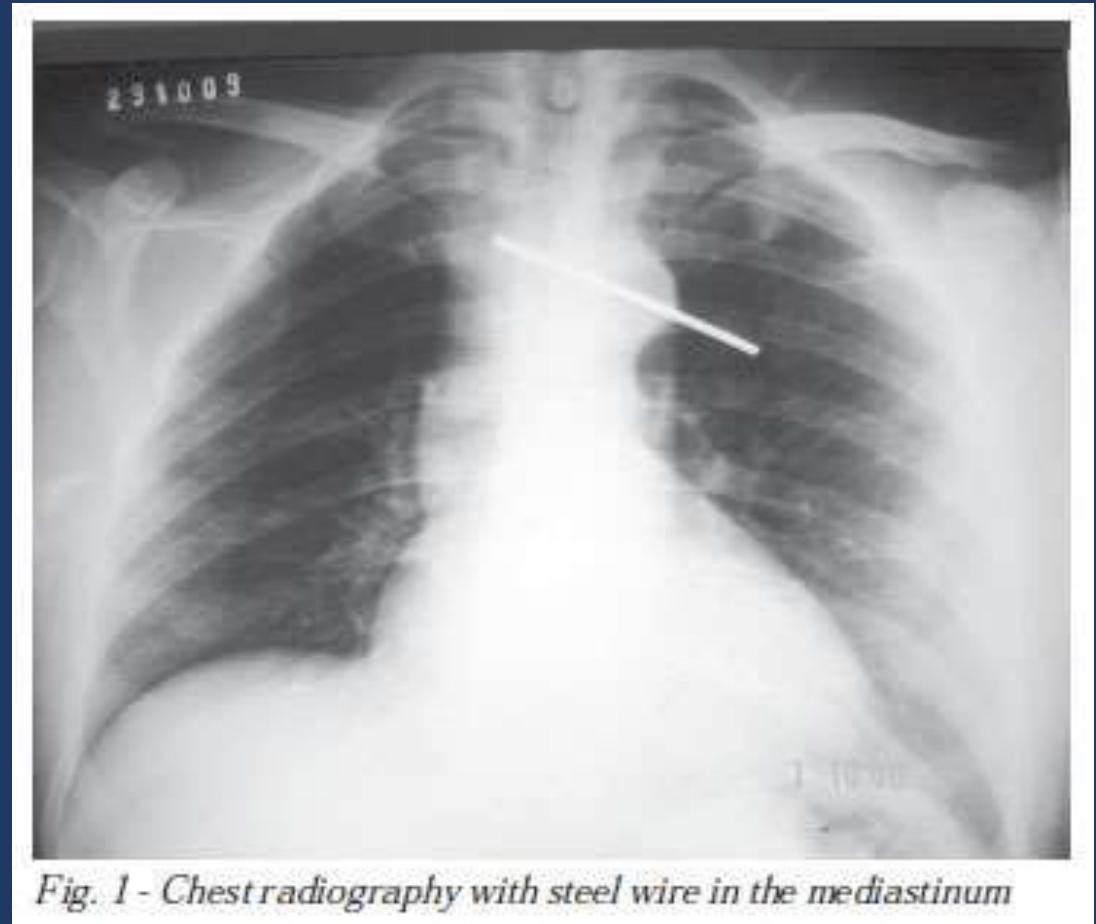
Chest radiography with steel wire in the mediastinum
